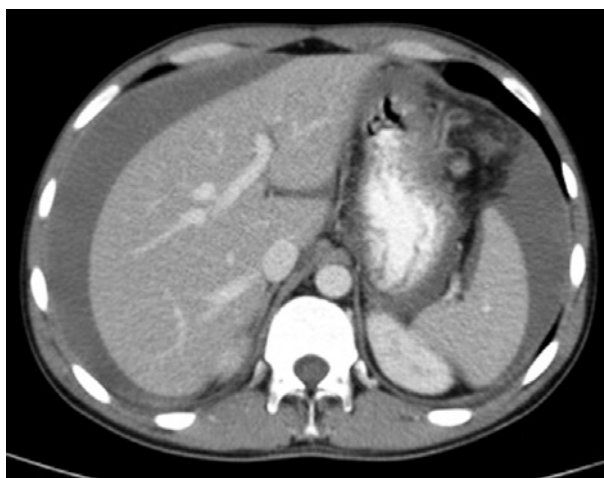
Computed tomography revealed a tumor in the greater curvature of the stomach, with heterogeneous contrast uptake, measuring 9.2x7.7cm
